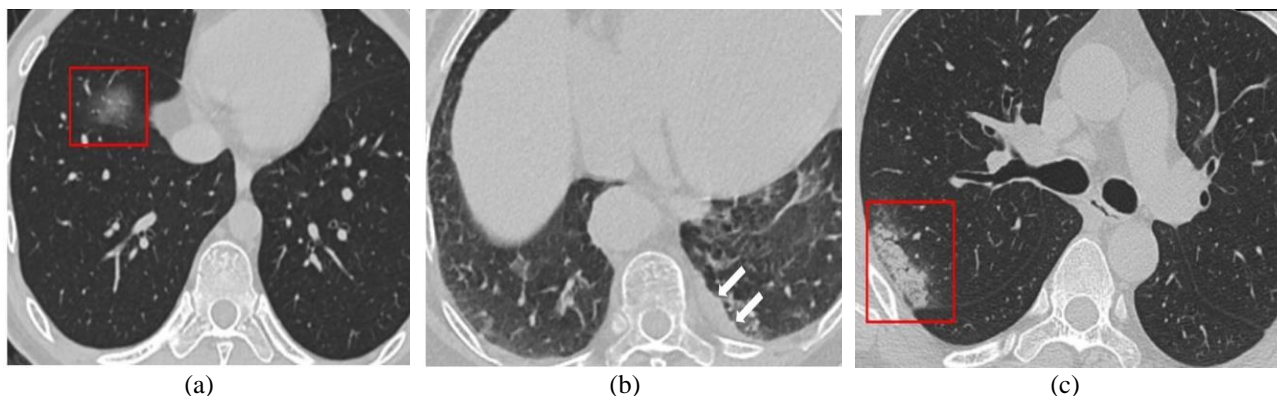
Example CT-scan of a COVID-19 patient with: (a) GGO, (b) Pleural changes, and (c) consolidation [1]
